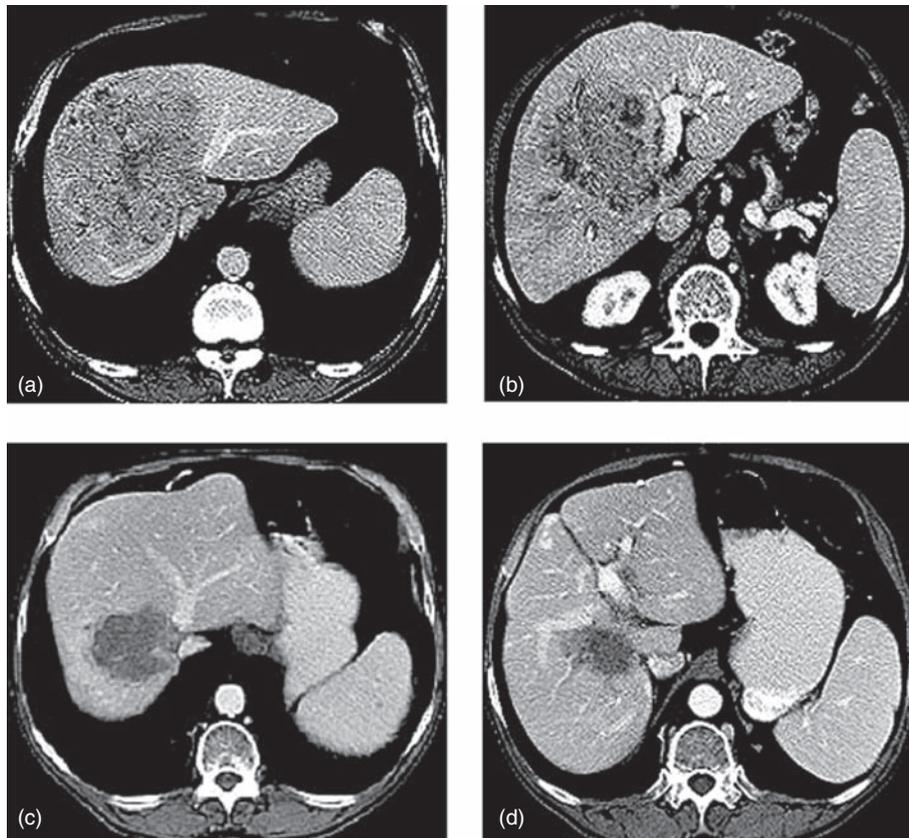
Hepatic arterial infusion chemotherapy for intrahepatic cholangiocarcinoma. (a) and (b) Axial computed tomography (CT) images with intravenous contrast show a large predominantly right-sided intrahepatic cholangiocarcinoma at presentation. (c) and (d) After hepatic arterial infusion chemotherapy with floxuridine dramatic tumor shrinkage was observed.
